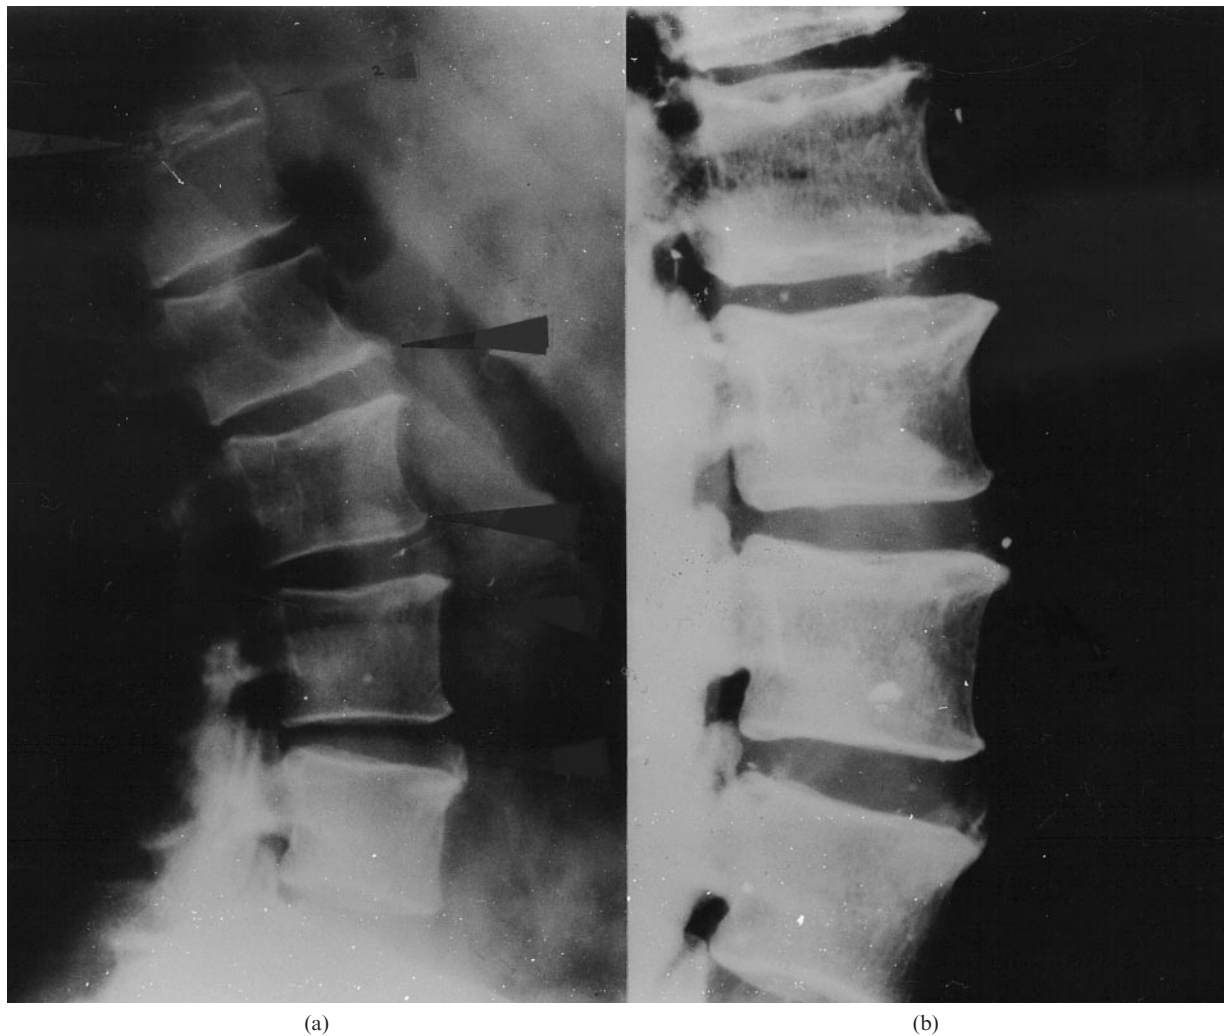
Torso recovered within the rubble in a mass disaster. (a) Ante-mortem radiograph of thoracic and lumbar spine showing age related morphological features. (b) Post-mortem radiograph showing similar characteristics.
